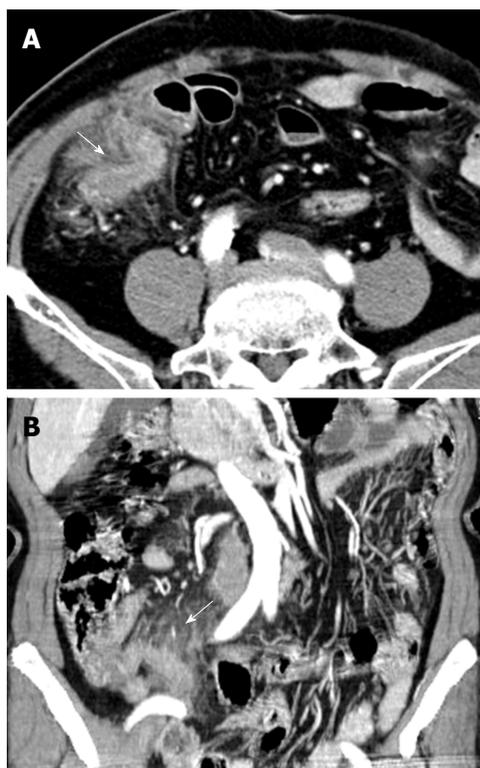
Fat stranding. A: Cross-sectional (arrow); B: Coronal abdominal computed tomography scans showing periappendiceal fat stranding suggestive of acute appendicitis (arrow).
